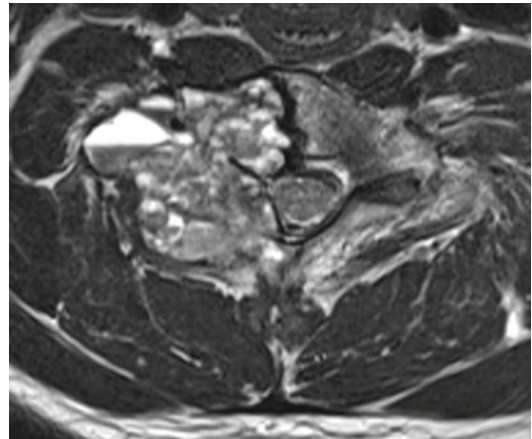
MRI of same patient of Fig. 31.3, aneurysmal bone cyst showing typical fluid-fluid levels
